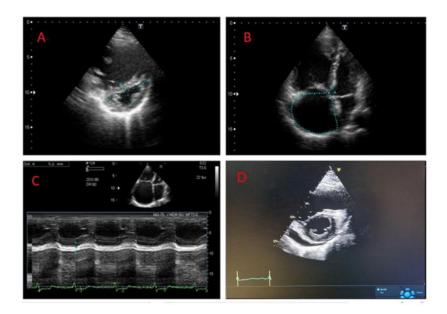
The most important echocardiographic parameters characteristic of the right ventricle
